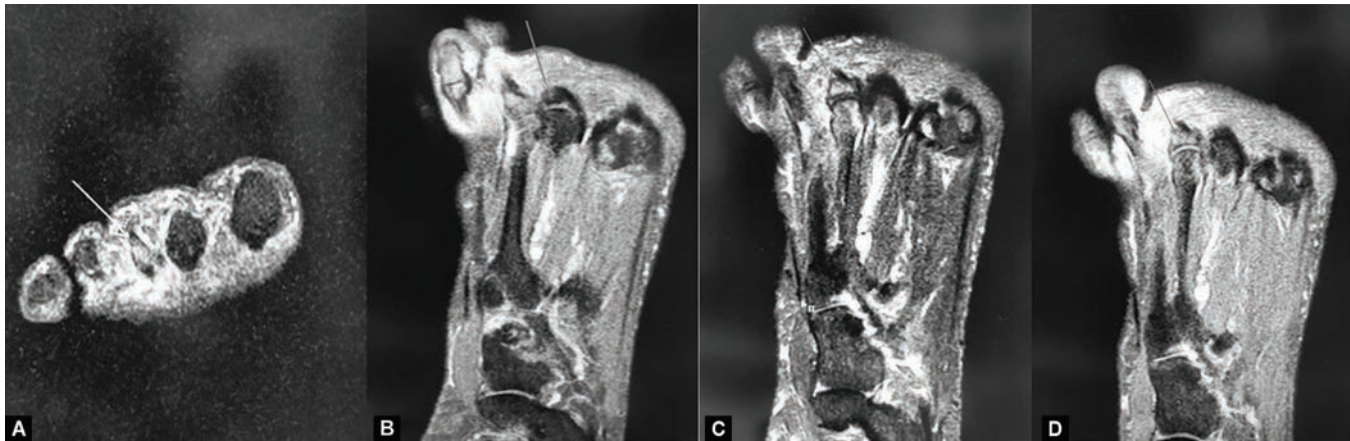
MRI right foot showed collection in 3rd MTP joint with marrow edema of adjoining bones suggestive of infective aetiology (Case 4)
